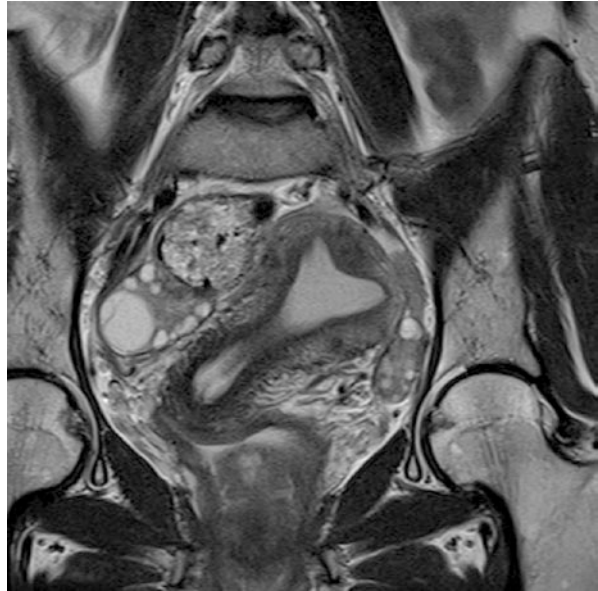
Coronal T2-weighted MR image showing an arcuate uterus which is deviated to left side
